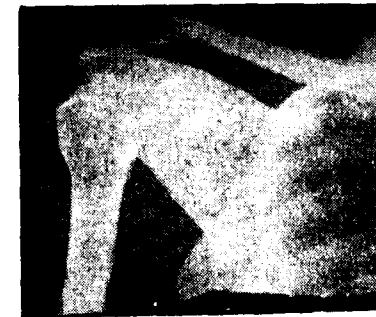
X-ray of the case in Fig. 3.
